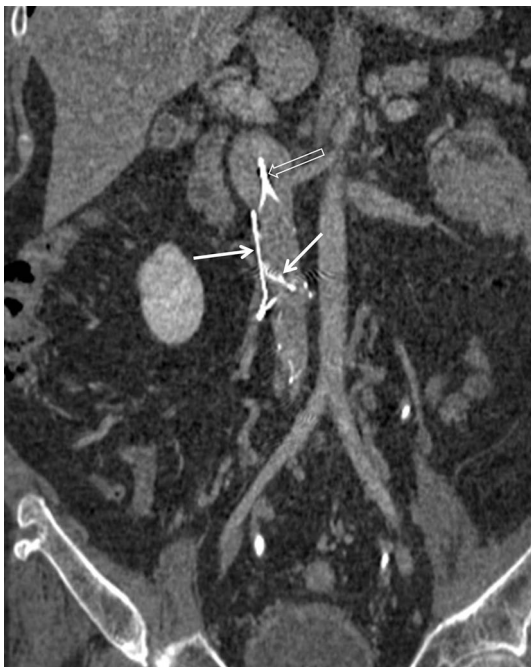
Fracture of inferior vena cava filter in a 40-year-old male with quadriplegia because of a traffic accident. Coronal reformatted CT scan shows multiple fractured filter fragments (*arrows*) in the inferior vena cava. Note the newly inserted filter (*open arrow*) in the inferior vena cava at the level of the *left* renal vein insertion
